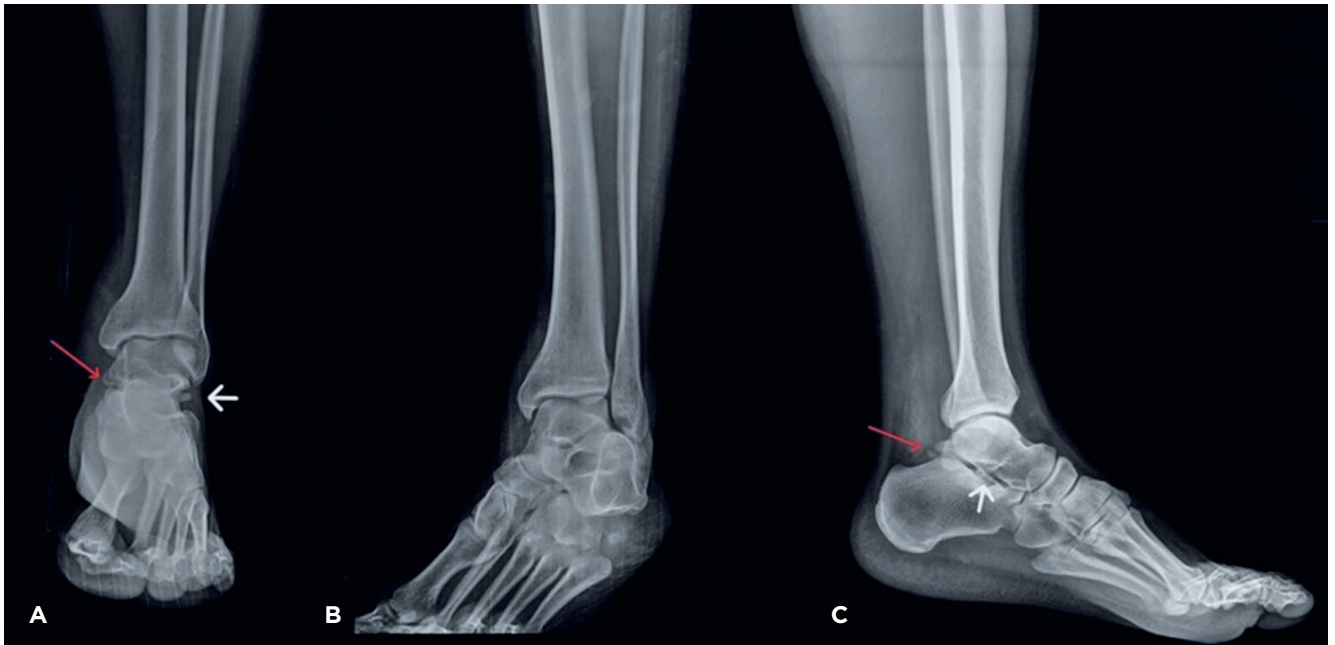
(A) Anteroposterior ankle radiograph. The short white arrow indicates a lateral peritalar bony double contour in the subfibular region, suggesting a fracture of the lateral process of the talus. The red arrow highlights a double contour of the medial talus, suggesting a fracture of the posteromedial process. (B) A lateral radiograph shows soft tissue swelling in the ankle. (C) A mortise radiograph; the red arrow points to the fracture line in the posterior process of the talus, and the white arrow shows the altered V-sign, which corresponds to disruption of the normal cortical outline formed by the lateral talar process and the posterior subtalar joint, and serves as an indirect indicator of fracture.
